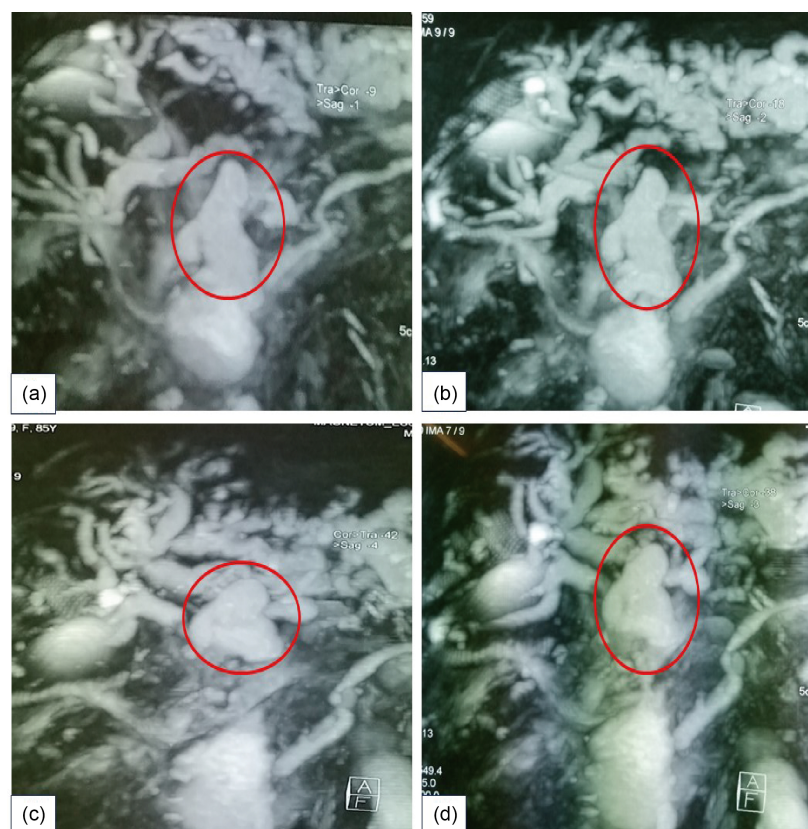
Bili-MRI showing a suspicious nodular signal thickening of the vaterian ampulla measured at 14 × 13 mm with bile duct ectasia and the main pancreatic duct (Wirsung) suggestive of a vaterian ampulloma (patient number 2).
